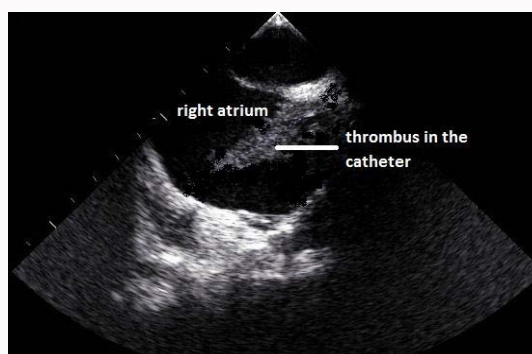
Echocardiography showing a large clot attached to hemodialysis catheter in right atrium.
